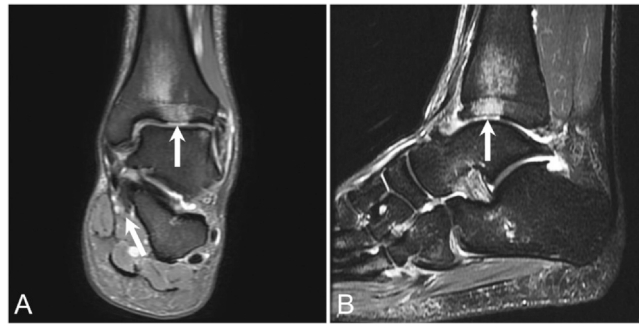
Professional basketball power forward presents for a baseline MRI before the start of the season. Coronal T2 FS (A) and sagittal short tau inversion recovery (STIR) (B) MR images of the ankle show a large measurable full-thickness cartilage defect (arrow in A and B) at the anterior tibial plafond with surrounding subchondral bone marrow edema extending into the distal tibia. FS, fat saturation; MR, magnetic resonance; MRI, magnetic resonance imaging.
